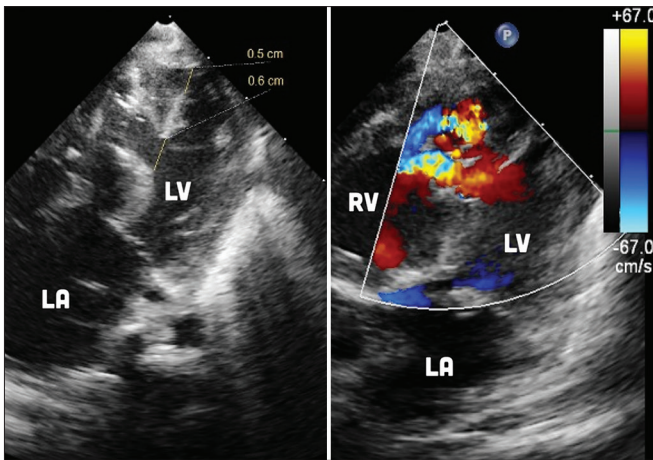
Postoperative echocardiogram shows significant left-to-right shunt through large, surgically challenging residual ventricular septal defects. LA: Left atrium, LV: Left ventricle, RV: Right ventricle
